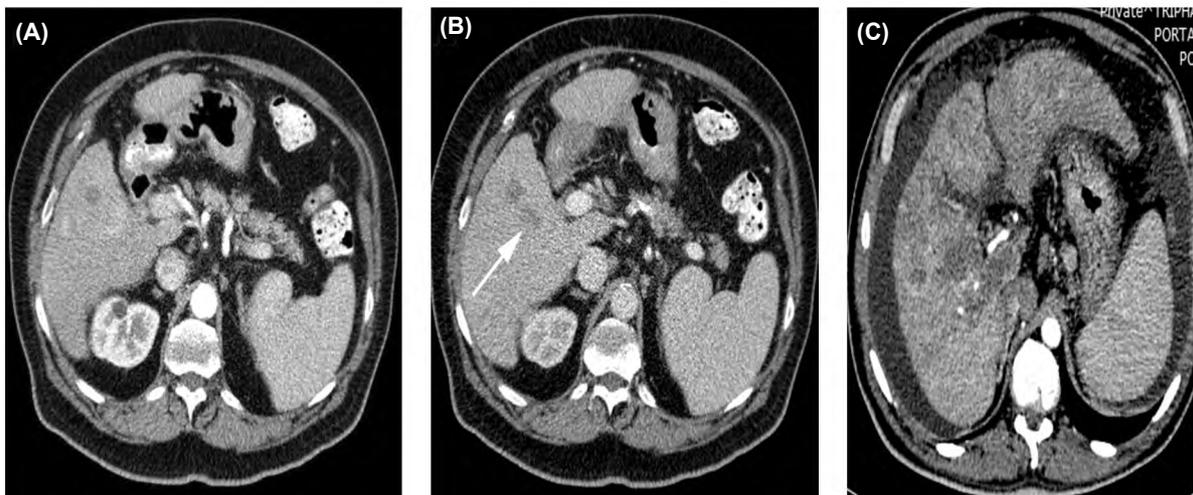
(A,B): Axial CT images showing multiple enhancing focal lesions involving the right lobe of the liver, and showing element of contrast washout (arrow) (C): Axial CT scan 6month post Y radioembolization showing tumor progression with portal vein invasion as well as newly developed perihepatic ascites.
